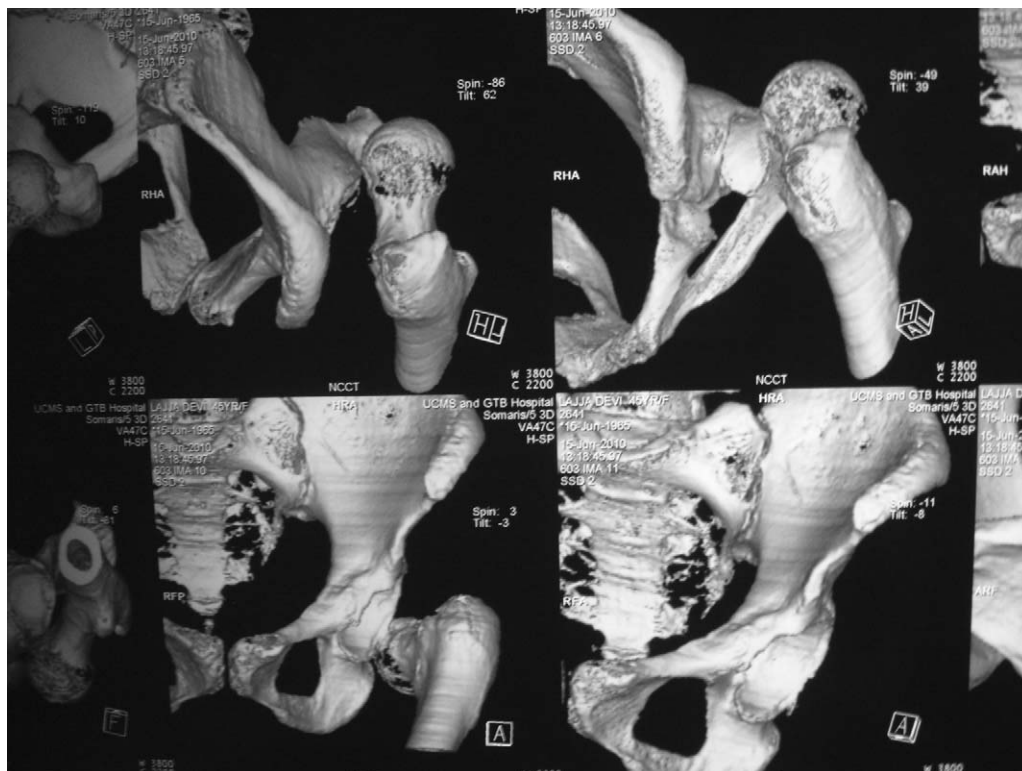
CT scan 3D reconstruction images including head subtraction view to show intact acetabulum.
